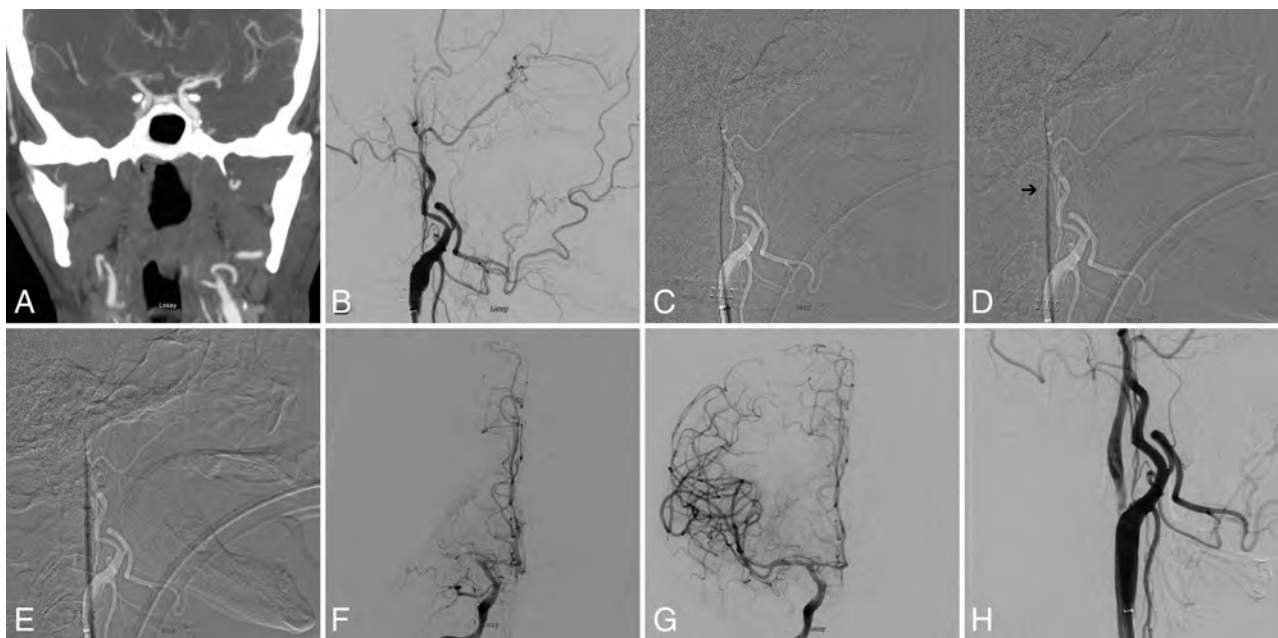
A, Preprocedural CTA showing acute occlusion of right MCA. Note nonopacification of cervical right ICA. B, Digital subtraction angiogram of the right common carotid artery in a lateral view shows occlusion of cervical ICA at the origin. C, Subtracted fluoroscopic roadmap shows crossing of the cervical ICA occlusion with a Glidewire, followed by the Neuron MAX 088 inner dilator (D). Despite radiolucency of the dilator, note the subtle change in Glidewire angulation indicating the dilator tip location (arrow). E, Subsequent dilator-Dotter angioplasty by crossing the ICA occlusion with the Neuron MAX 088. Note the lack of dilator-catheter “step-off.” F, Angiogram in a frontal view shows tandem intracranial occlusion of right MCA, with subsequent successful thrombectomy (G) yielding a TICI 3 recanalization. H, The patient is left with 80% stenosis on the final postinterventional angiogram, which eventually asymptotically reoccluded.
